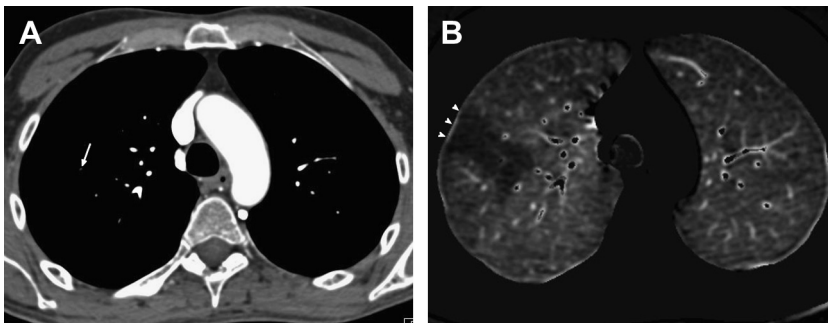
Dual-energy chest computed tomography (CT) angiography obtained in a 56-year-old man (175 cm; 58 kg) with suspected acute pulmonary embolism (PE). The examination was obtained with dual-source, dual-energy CT (tube A: 80 kV; tube B: 140 kVp; 35% iodinated contrast agent; flow rate: 4 mL/s). The dose-length-product was 374 mGy-cm. (A) Presence of a small-sized peripheral clot in a subsegmental pulmonary artery of the axillary area (arrow). (B) Whereas the small clot is difficult to visualize, the corresponding perfusion defect (small arrowheads) is easily seen.
